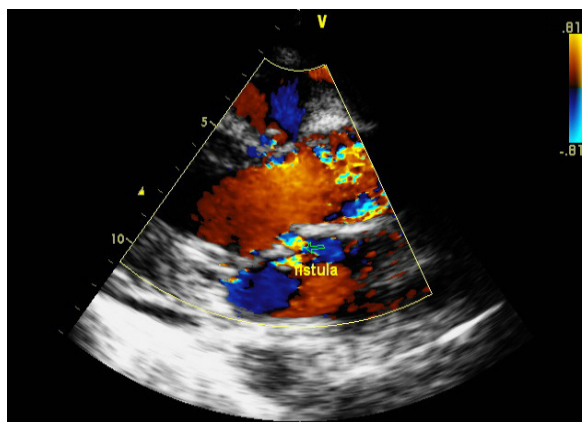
In the region of the abscess, there is perforation associated, evidenced by color Doppler.
